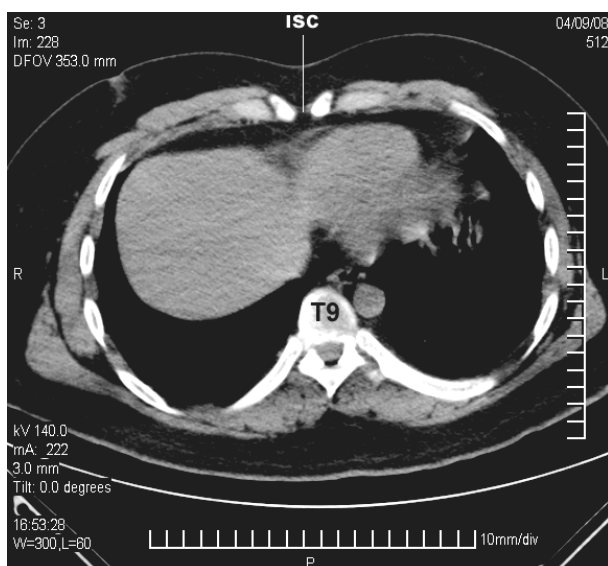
Chest CT of patient with inferior sternal cleft at the level of T9 vertebra.
